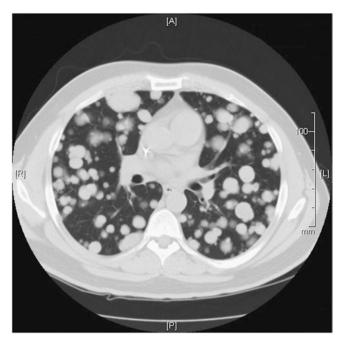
Contrast-enhanced CT image from a patient with metastatic extraskeletal myxoid chondrosarcoma, alive over 5 years after diagnosis of metastatic disease
